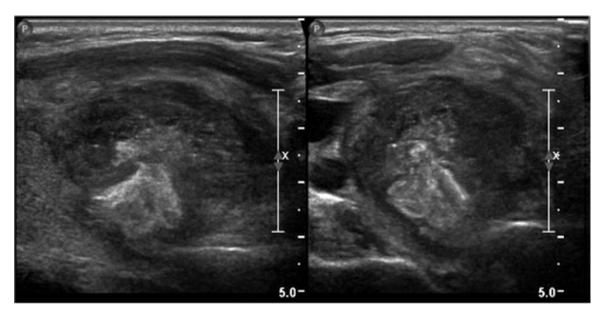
Post-fine-needle aspiration biopsy ultrasound of a right thyroid nodule performed May 11, 2021.
